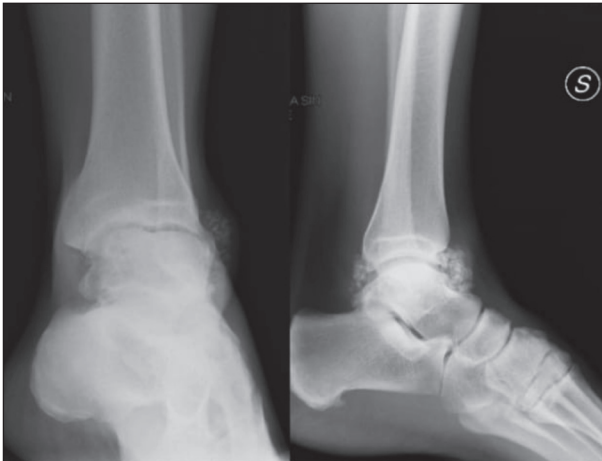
X-ray shows multiple lesions in all ankle compartments with typical characteristic and radio-densities of synovial chondromatosis.
